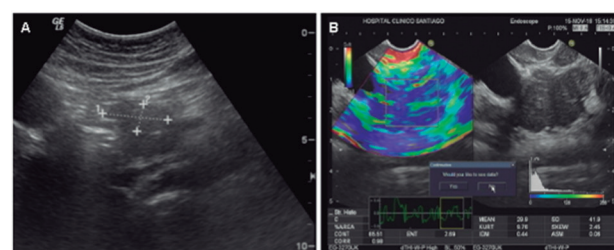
Ultrasound images corresponding to a 15-year-old male presenting with extrahepatic obstructive jaundice. He had been diagnosed with rhinoconjunctivitis and bronchial asthma with IgE-mediated sensitization to pollens and mites. A, Standard abdominal ultrasound showing a 3×2 cm hypoechoic mass in the head of the pancreas. B, Endoscopic ultrasound confirming the heterogeneous pancreatic mass; elastography for evaluation of stiffness reveals a hard (predominantly blue) pattern with a strain ratio >10. Serum IgG4 was 147 mg/dL, and serum IgE was 59 U/L. Autoimmune pancreatitis in this case could be classified as focal according to the criteria of Vlachou et al [58]. The pancreatic lesion and obstructive jaundice gradually resolved with corticosteroids.
